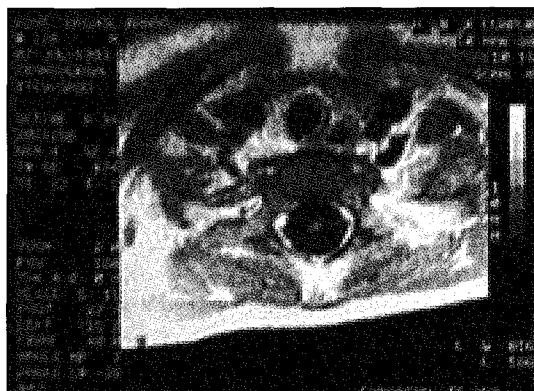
MRI films taken three months after the injury showing spinal cord atrophy.
